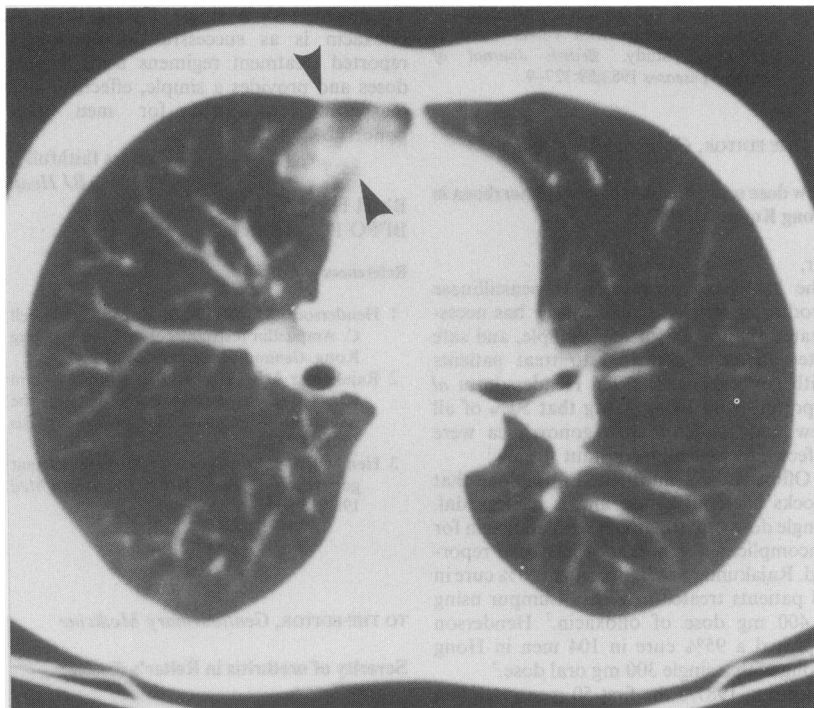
Fig Computed tomography showing infiltration (arrowed) in right lung mid zone.
